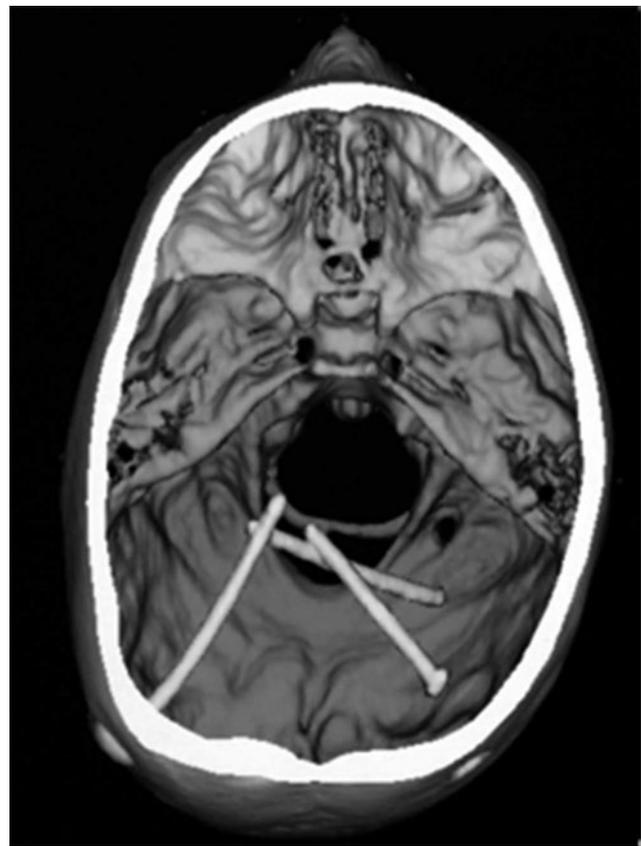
Retained shunt tubing. 3D CT scan showing retained ventricular catheters. Successful treatment of a shunt infection requires the removal of all catheter tubing.
